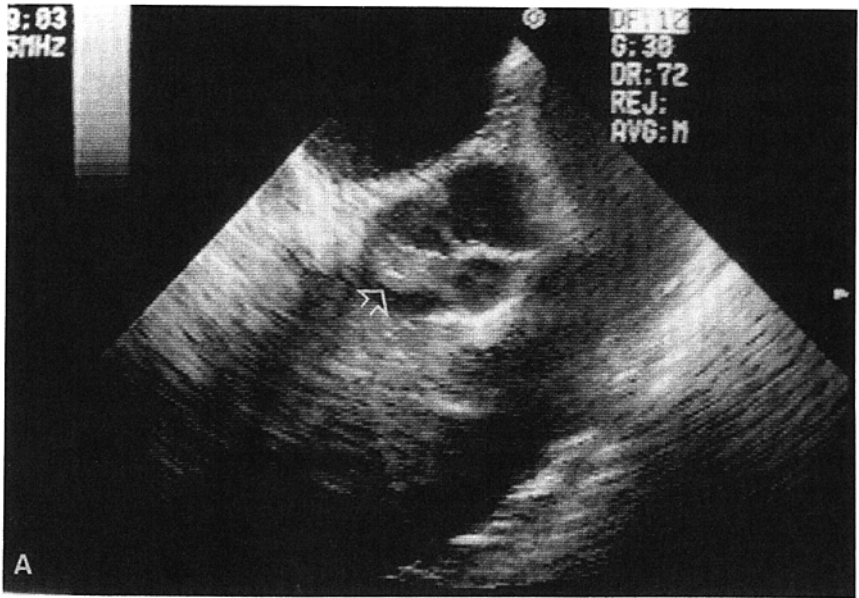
Vegetation on an aortic valve. (A) Transesophageal sonogram through the aortic valve demonstrates an infected thrombus on the non-coronary cusp of the aortic valve (open arrow), in a patient with endocarditis. (B) Transesophageal sonogram in an oblique plane shows the left atrium (LA) with its atrial appendage (open arrow). Posterior to the atrium is the aortic valve and root with the thrombus (arrow) protruding from the valve into the outer tract of the left ventricle (LV). (Courtesy of Dr. Greg Schwartz, Veterans Administration Medical Center, San Francisco, California.)
